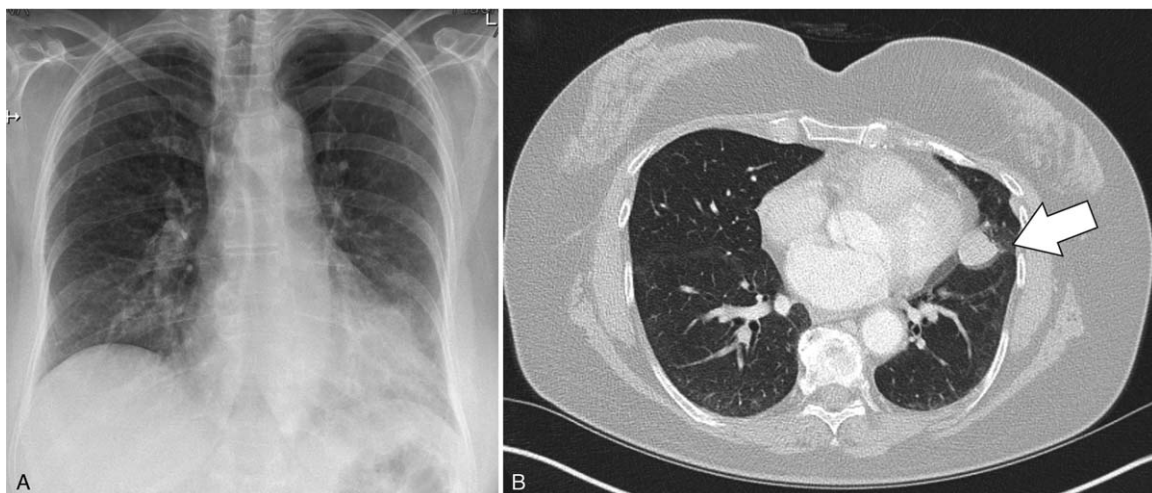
Radiological examination of the chest of the patient. (A) Radiograph of the chest revealed an uneven mass in the left lung. (B) Chest CT scan displayed a paracardiac tumor (arrow).
